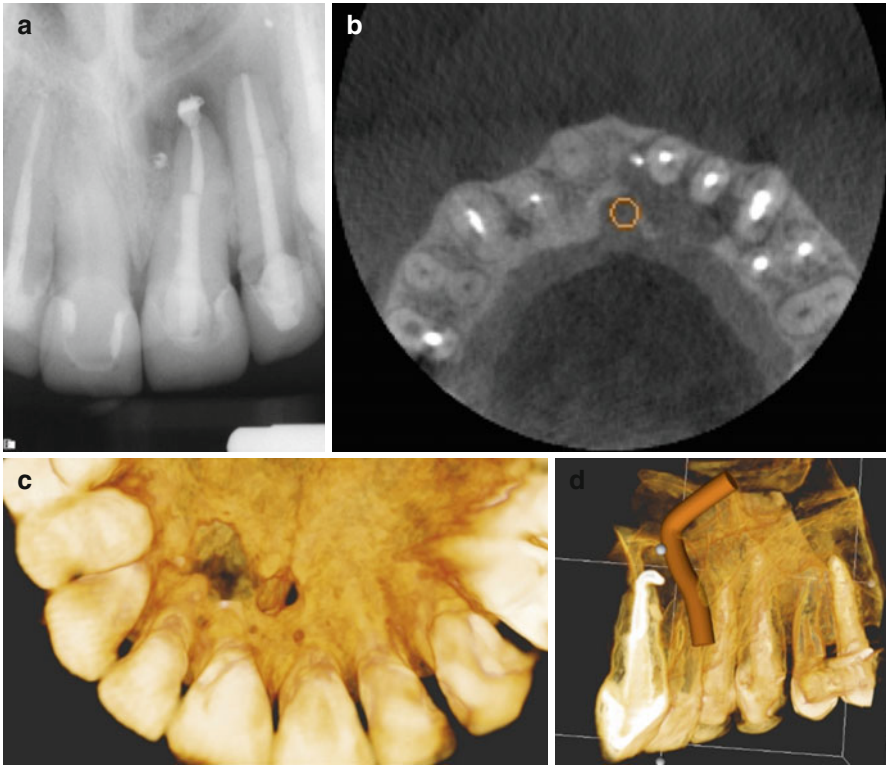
(a) Periapical radiograph of the maxillary anterior region showing a periapical lesion associated with tooth #9. (b) Axial view showing the extent of the lesion, palatal plate perforation, and relationship of the nasopalatine neurovascular bundle to the periapical lesion. (c) Palatal view of the 3D reconstruction showing perforation of the palatal plate. (d) 3D reconstruction showing the nasopalatine bundle
